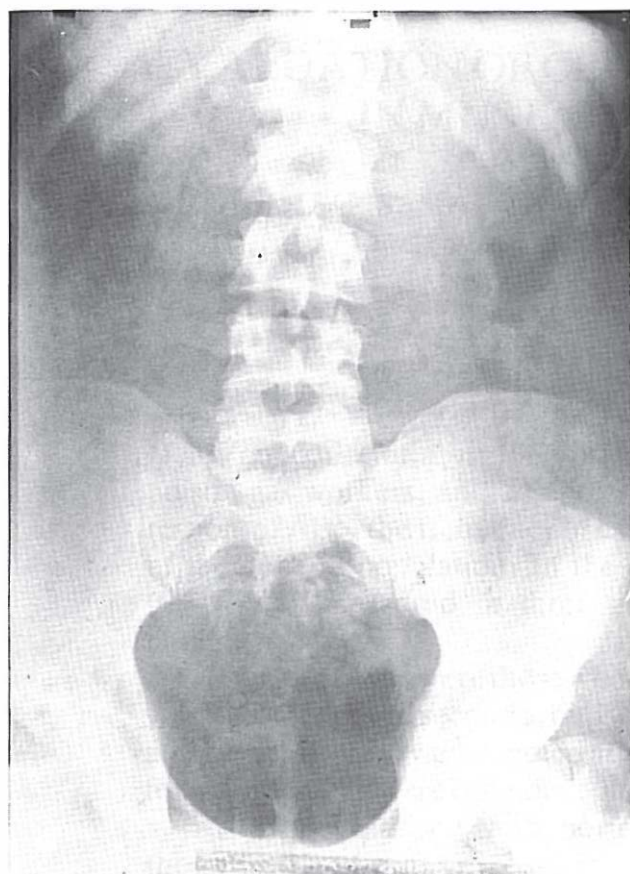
Plain film showing fragmentation of stone with electrohydraulic shock wave.
